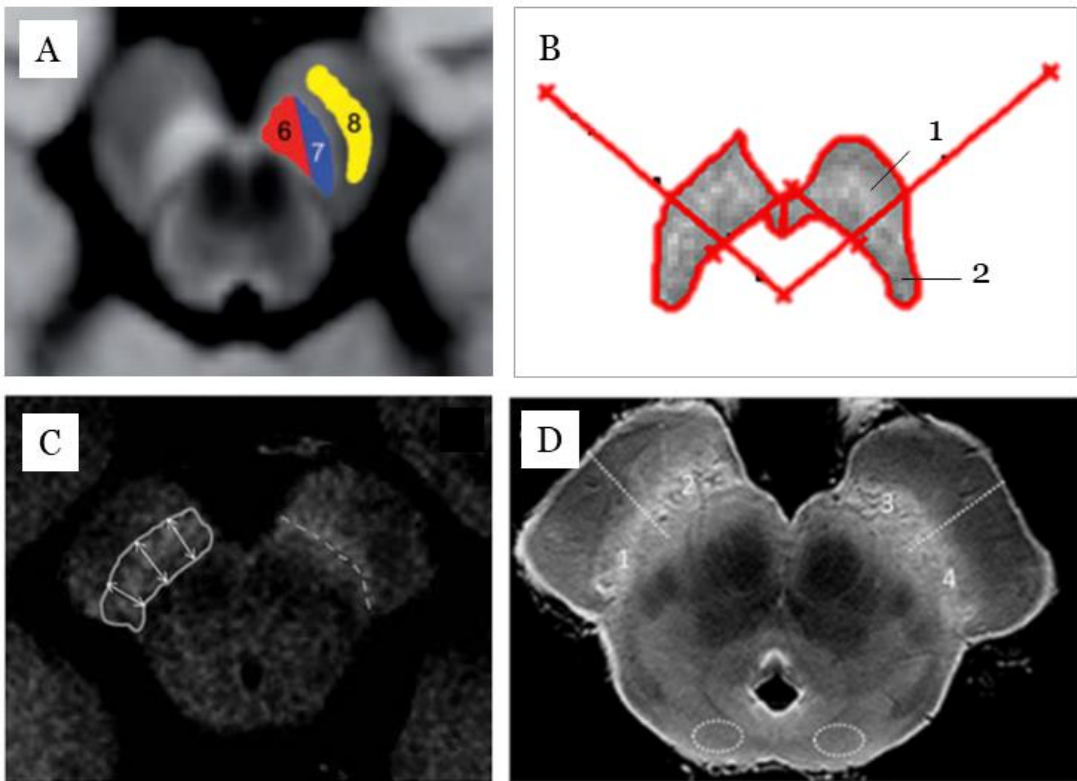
Subdivisions of substantia nigra in various MRI studies. A - Divisions into “dorsal SN” (6, red on the picture) and “ventral SN” (7, blue on the picture) of the SN on an axial slice of a neuromelanin-sensitive MRI. Picture reproduced from (Martín-Bastida *et al.*, 2019). B - Divisions into “anterior SN” (1) and “posterior SN” (2) of the SN, on an axial slice. Picture reproduced from (Schwarz *et al.*, 2017). The line dividing the SN in these two studies are drawn in orthogonal directions. C - Divisions of SN into “medial”, “central” and “lateral SN”, on an axial slice. Picture reproduced from (Reimão *et al.*, 2015). D- Divisions of SN into “medial SN” (2,3 on the picture) and “lateral SN” (1,4 on the picture) on a *post-mortem* NM-sensitive MRI of the midbrain. Picture reproduced from (Kitao *et al.*, 2013).
